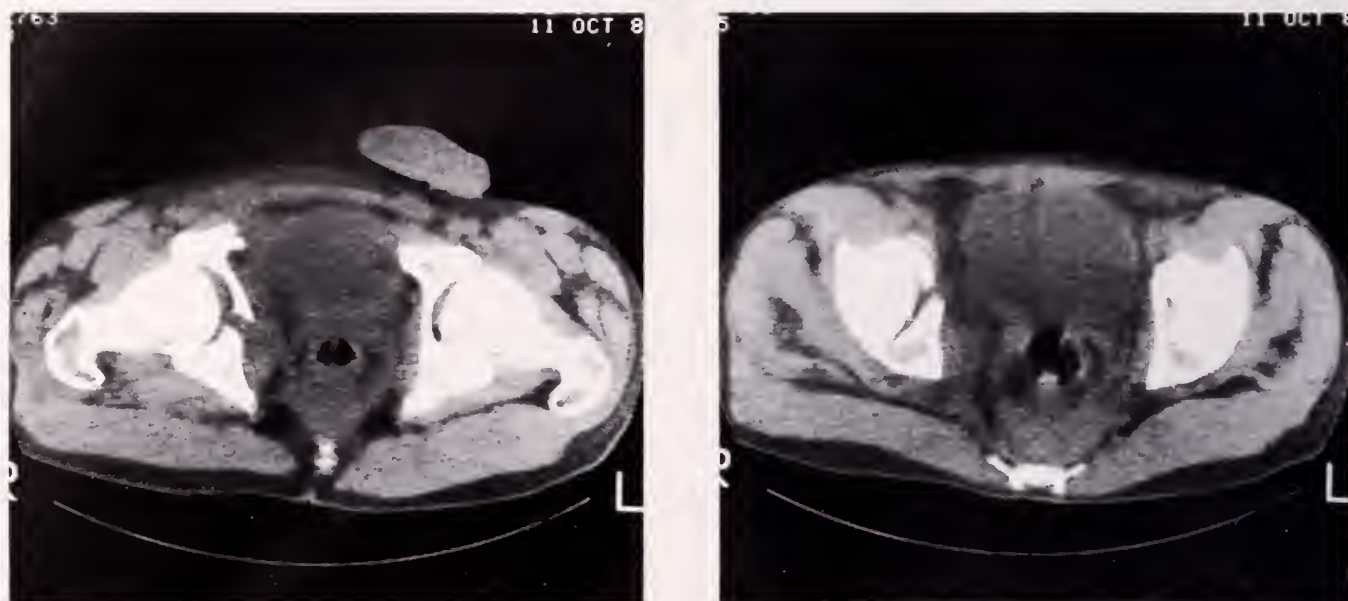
(A)CT scan at the level of the acetabular fossa shows a fracture of the medial wall of the right acetabulum. (B)In the same case, CT scan at the level of the roof of the acetabulum in the same case shows a comminuted fracture of the right acetabular roof.
